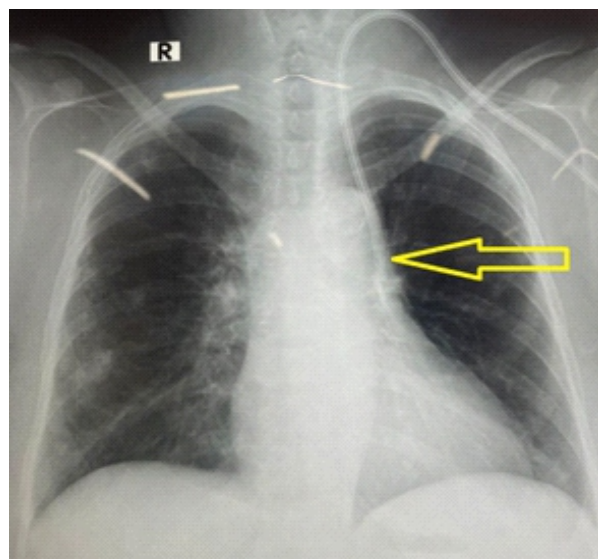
Chest X-ray showing the dialysis access line descending vertically downwards on the left side of the heart (arrow)
